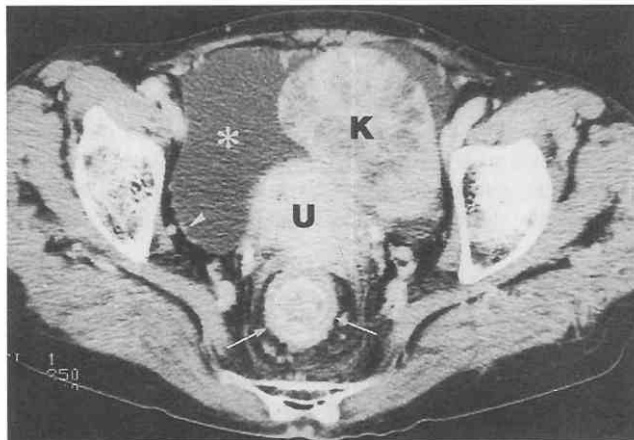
Metastatic tumor of the rectum with Krukenberg's tumor of the ovary after gastrectomy for gastric cancer. CT scan shows concentric thickening (arrows) of the rectal wall with the "target sign." The surface of the uterus (U) appears irregular, and there is evidence of a left ovarian mass (K), ascites (asterisk), and focal thickening of the peritoneum (arrowhead). (From Ha HK, Jee KR, Yu E, et al: CT features of metastatic linitis plastica to the rectum in patients with peritoneal carcinomatosis. *AJR Am J Roentgenol* 174:463-466, 2000.)
